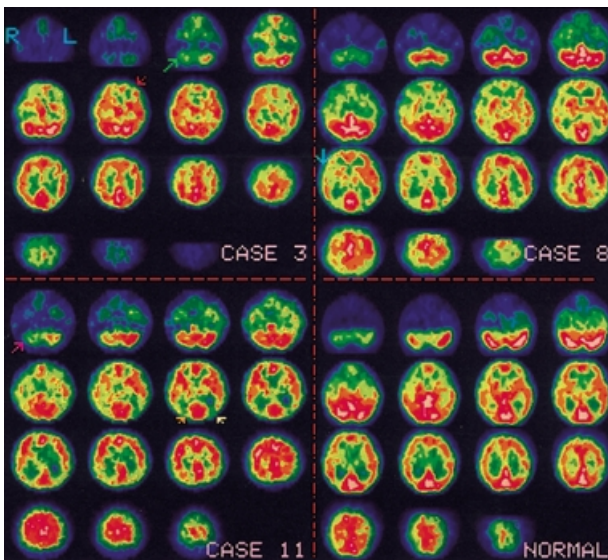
Upper left, case 3: hypoperfusion of left frontal brain (red arrow) and right cerebellum (green arrow); upper right, case 8: hypoperfusion of right hemisphere except cerebellum (blue arrow); lower left, case 11; hypoperfusion of bilateral rear temporoparietal brain (yellow and orange arrows) and right cerebellum (red arrow); lower right, normal SPECT scan from a healthy person. All images are transverse projections.
